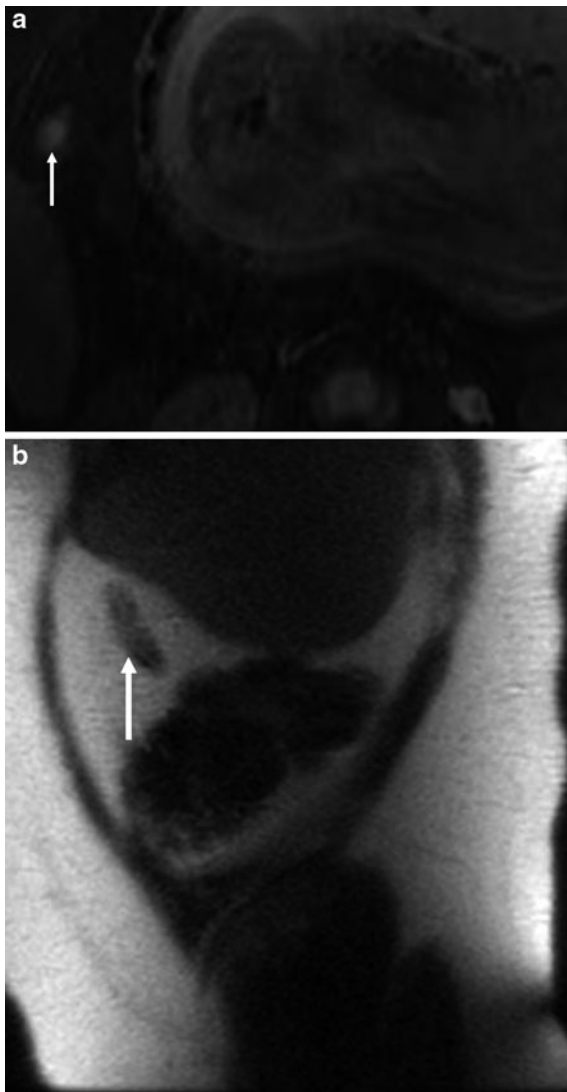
Mild appendicitis in a 29-year-old pregnant woman. Axial short inversion time inversion-recovery image (a) shows dilated, fluid-filled structure (arrow) with thickened wall and fat stranding, consistent with acute appendicitis. Coronal T2-weighted single-shot fast spin-echo image (b) shows the dilated, thick walled appendix with increased intramural signal (arrow)
